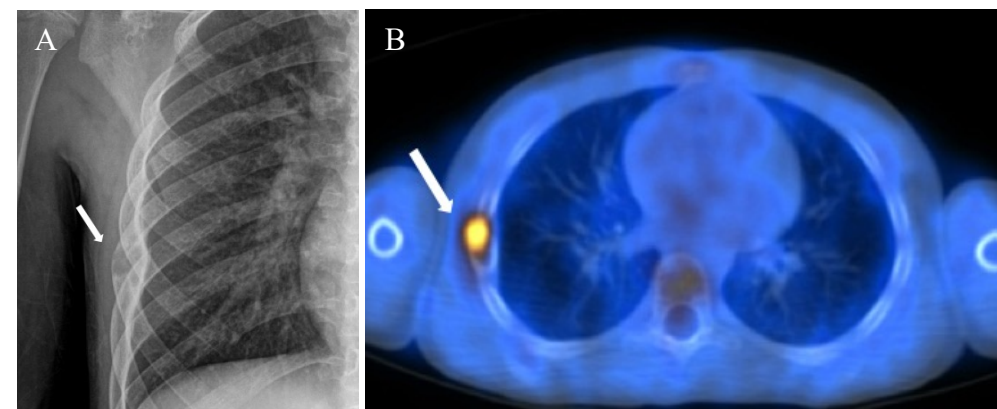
An eight year old female presenting with right sided rib pain (Case 7). (A) Anteroposterior radiographic scan demonstrating osteolytic lesion at the 6th rib. (B) Axial view of positron emission tomography (PET) scan demonstrating hyperintensity at the 6th rib.
